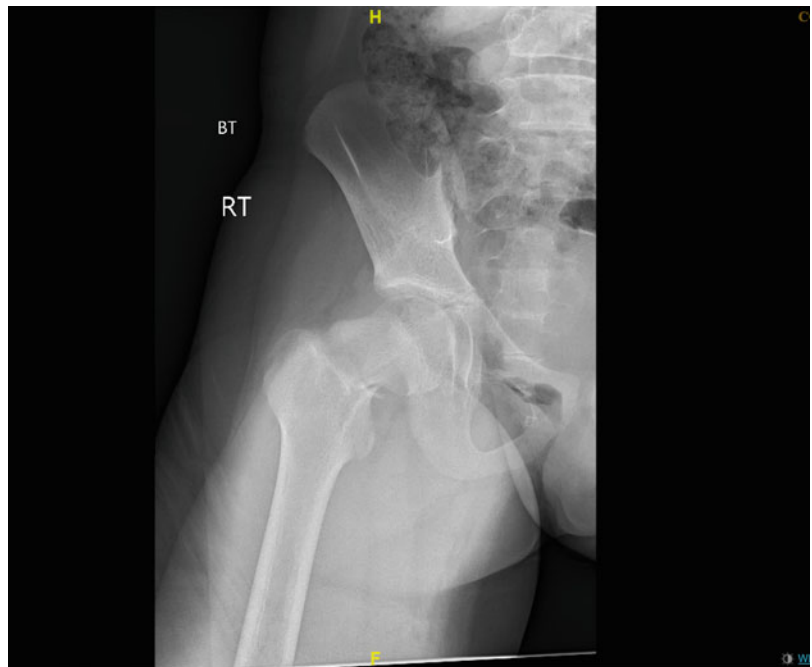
Coned down radiograph of the right hip. Note the inferior femoral neck comminution with displacement and angulation of the fracture
